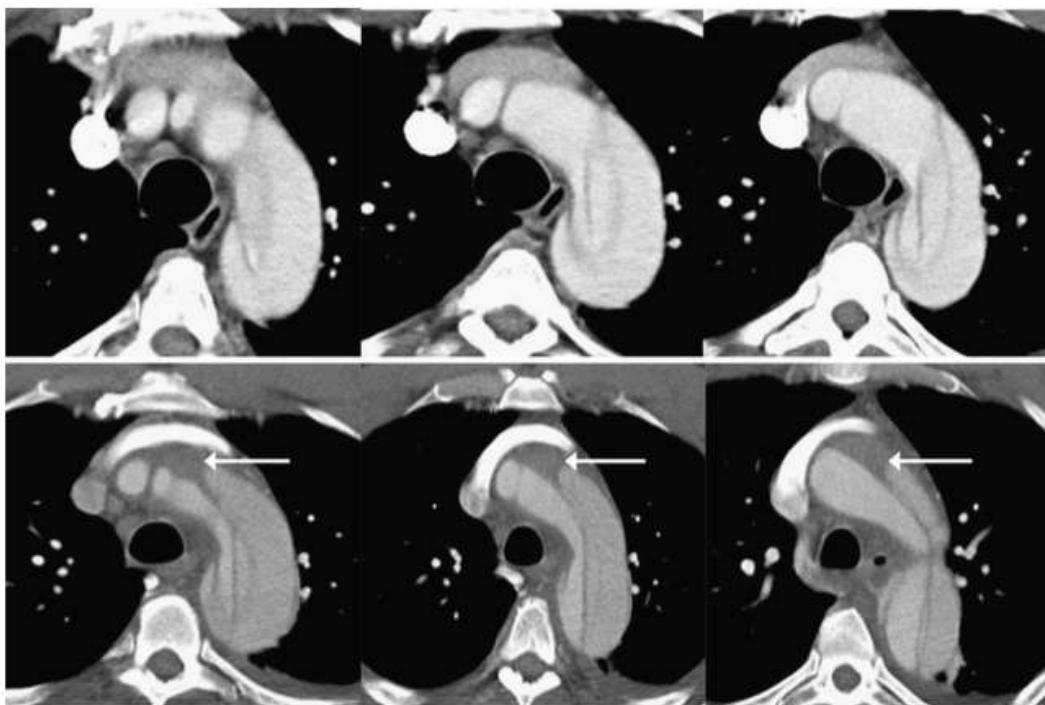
Comparison of axial computed tomography images at the level of the aortic arch performed when a patient was admitted for evaluation of acute chest and back pain (top row), and 4 days later when he experienced another episode of pain (bottom row). Interval proximal extension of the dissection process is evident with progression of aortic involve (continued thoracic imaging the ascending and aortic arch (arrows).
